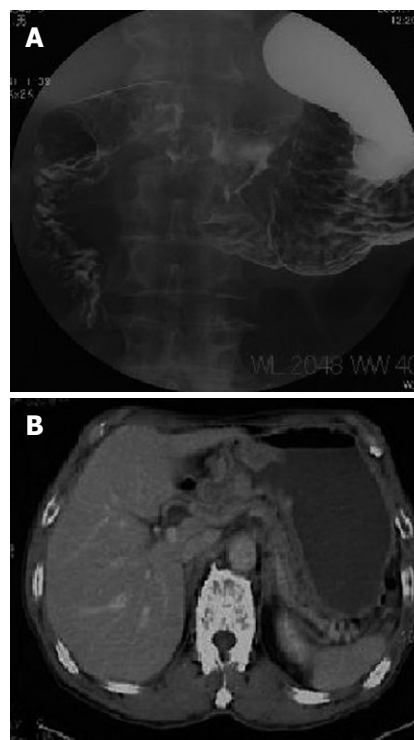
Gastrografen meal study revealing a tumor with ulceration at the gastric antrum, causing gastric outlet obstruction (A), and abdominal computed tomography scan showing remarkable thickness of gastric wall with no evidence of direct invasion to the pancreas head, and lymph node metastasis or distant metastasis (B).
